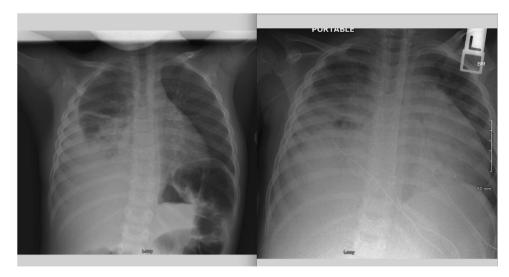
X-ray at admission and on day 6 of hospitalisation.
